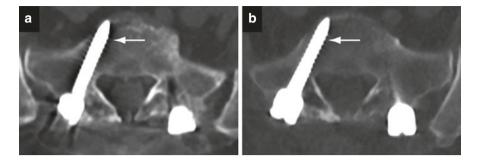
Spinal hardware metal artifact reduction on dual energy CT. Beam hardening artifact results in apparent lucency (arrow) around the right S1 pedicle screw (a) on a polyenergetic image at 120 kVp, but is demonstrated to be artifact on a virtual monoenergetic image at 135 kVp (b). Streak artifact around the pedicle screws is also significantly reduced in the virtual monoenergetic image allowing for better evaluation of osseous and soft tissue detail
